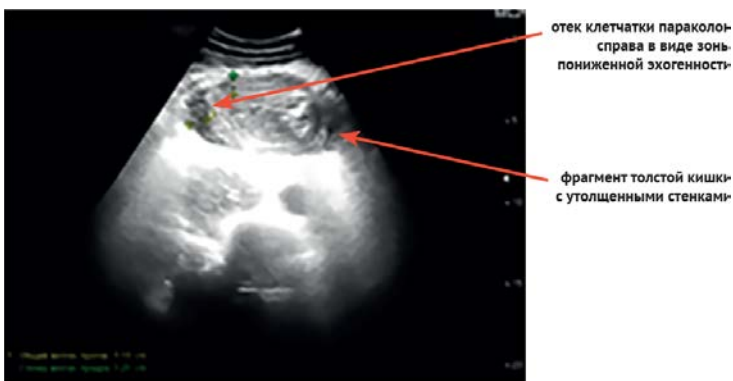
Ultrasound image of a fragment of the ascending colon with thickened walls of 1.1 cm thick, structure with medium echogenicity. Edema of paracolon tissue on the right with decreased echogenicity (expansion up to 7 mm)
